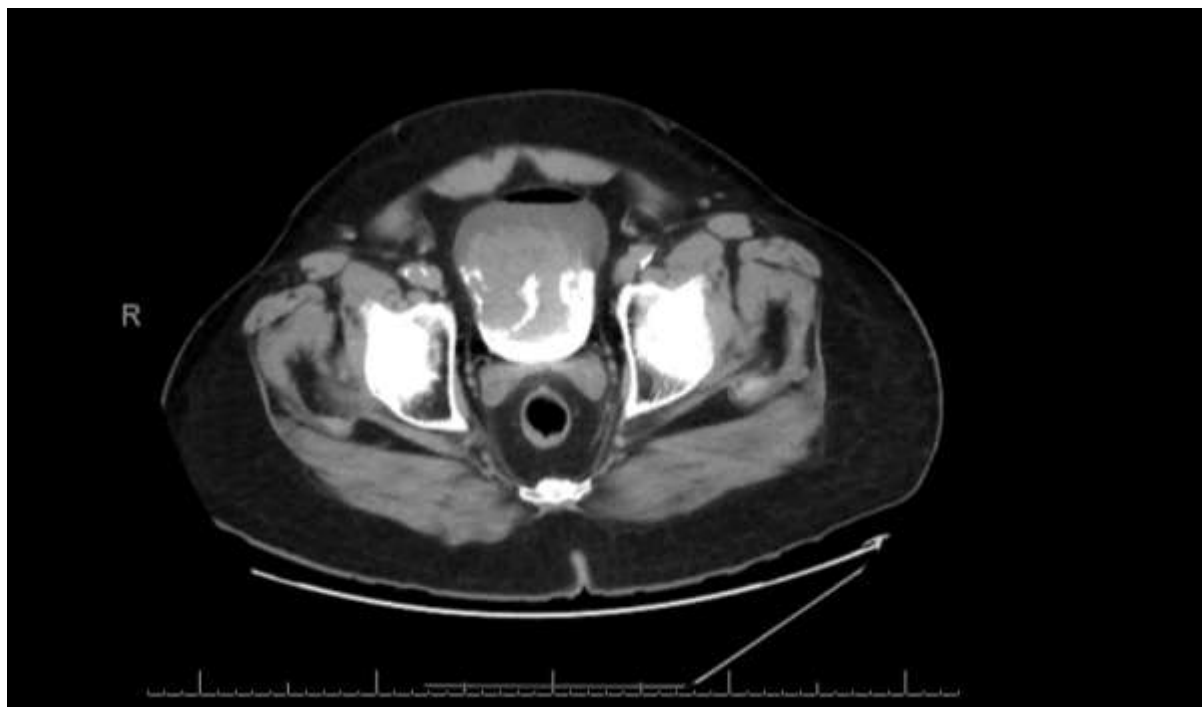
CT Urogram axial view showing lesion in the urinary Bladder.
